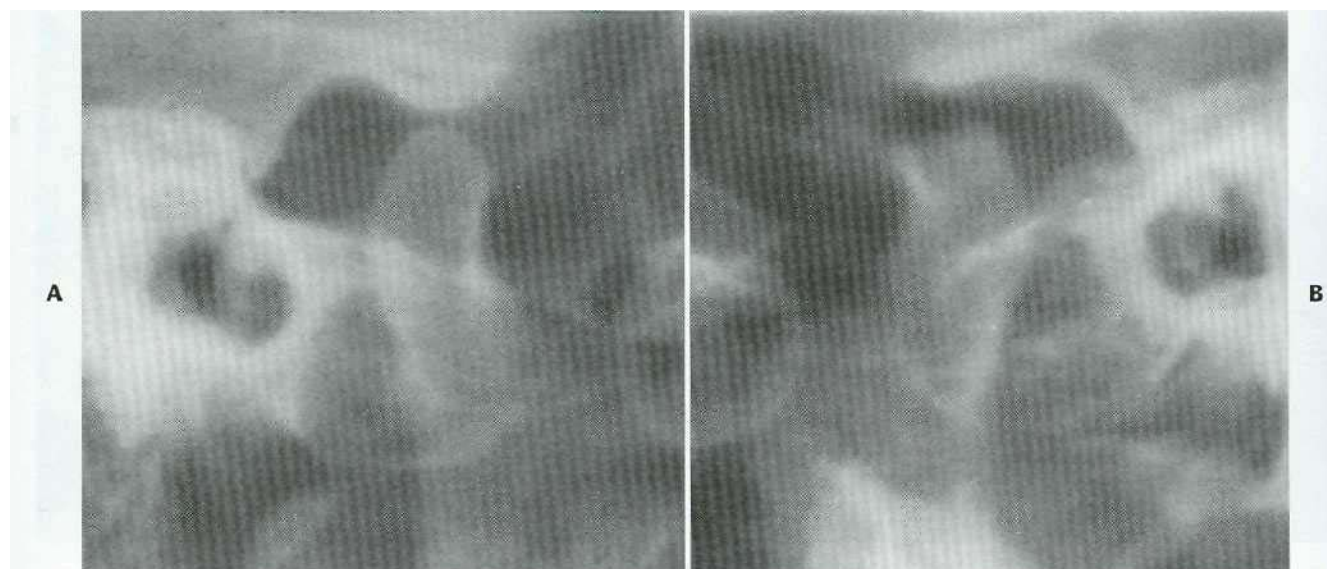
Examples of transcranial radiographs. A, Radiograph of right side shows normal anatomy of fossa and condyle. B, Left-side view demonstrates degenerative changes of condyle.
